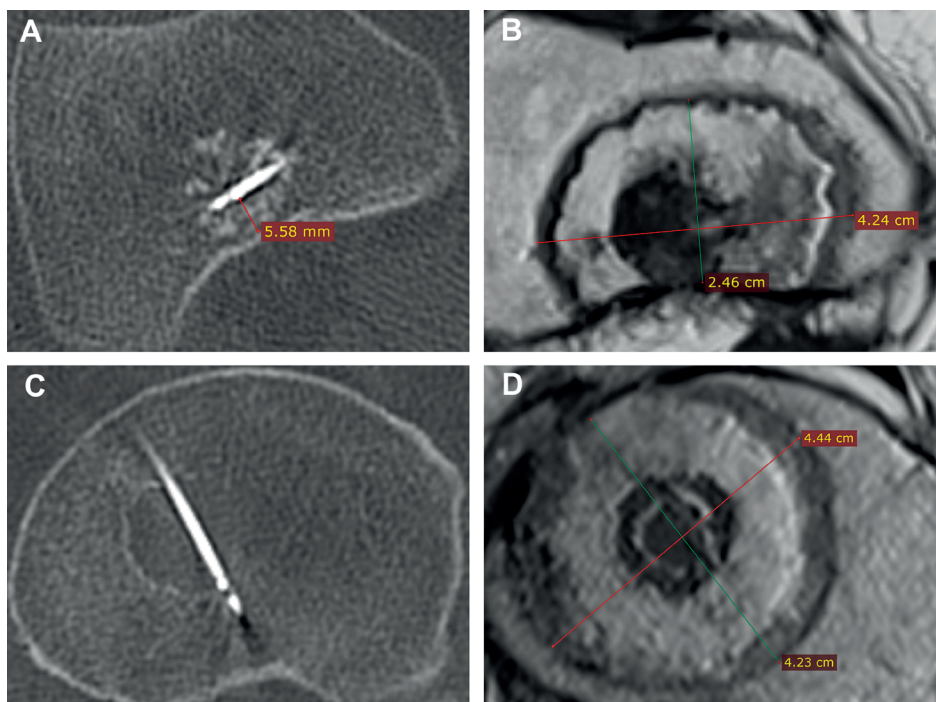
A, B: intraoperative CT and postoperative gadolinium-enhanced MR of a tumor ablated close to the cortical wall in a femur metaphysis. C, D: intraoperative CT and postoperative gadolinium-enhanced MR images of a centrally located tumor ablated in a femur metaphysis.
